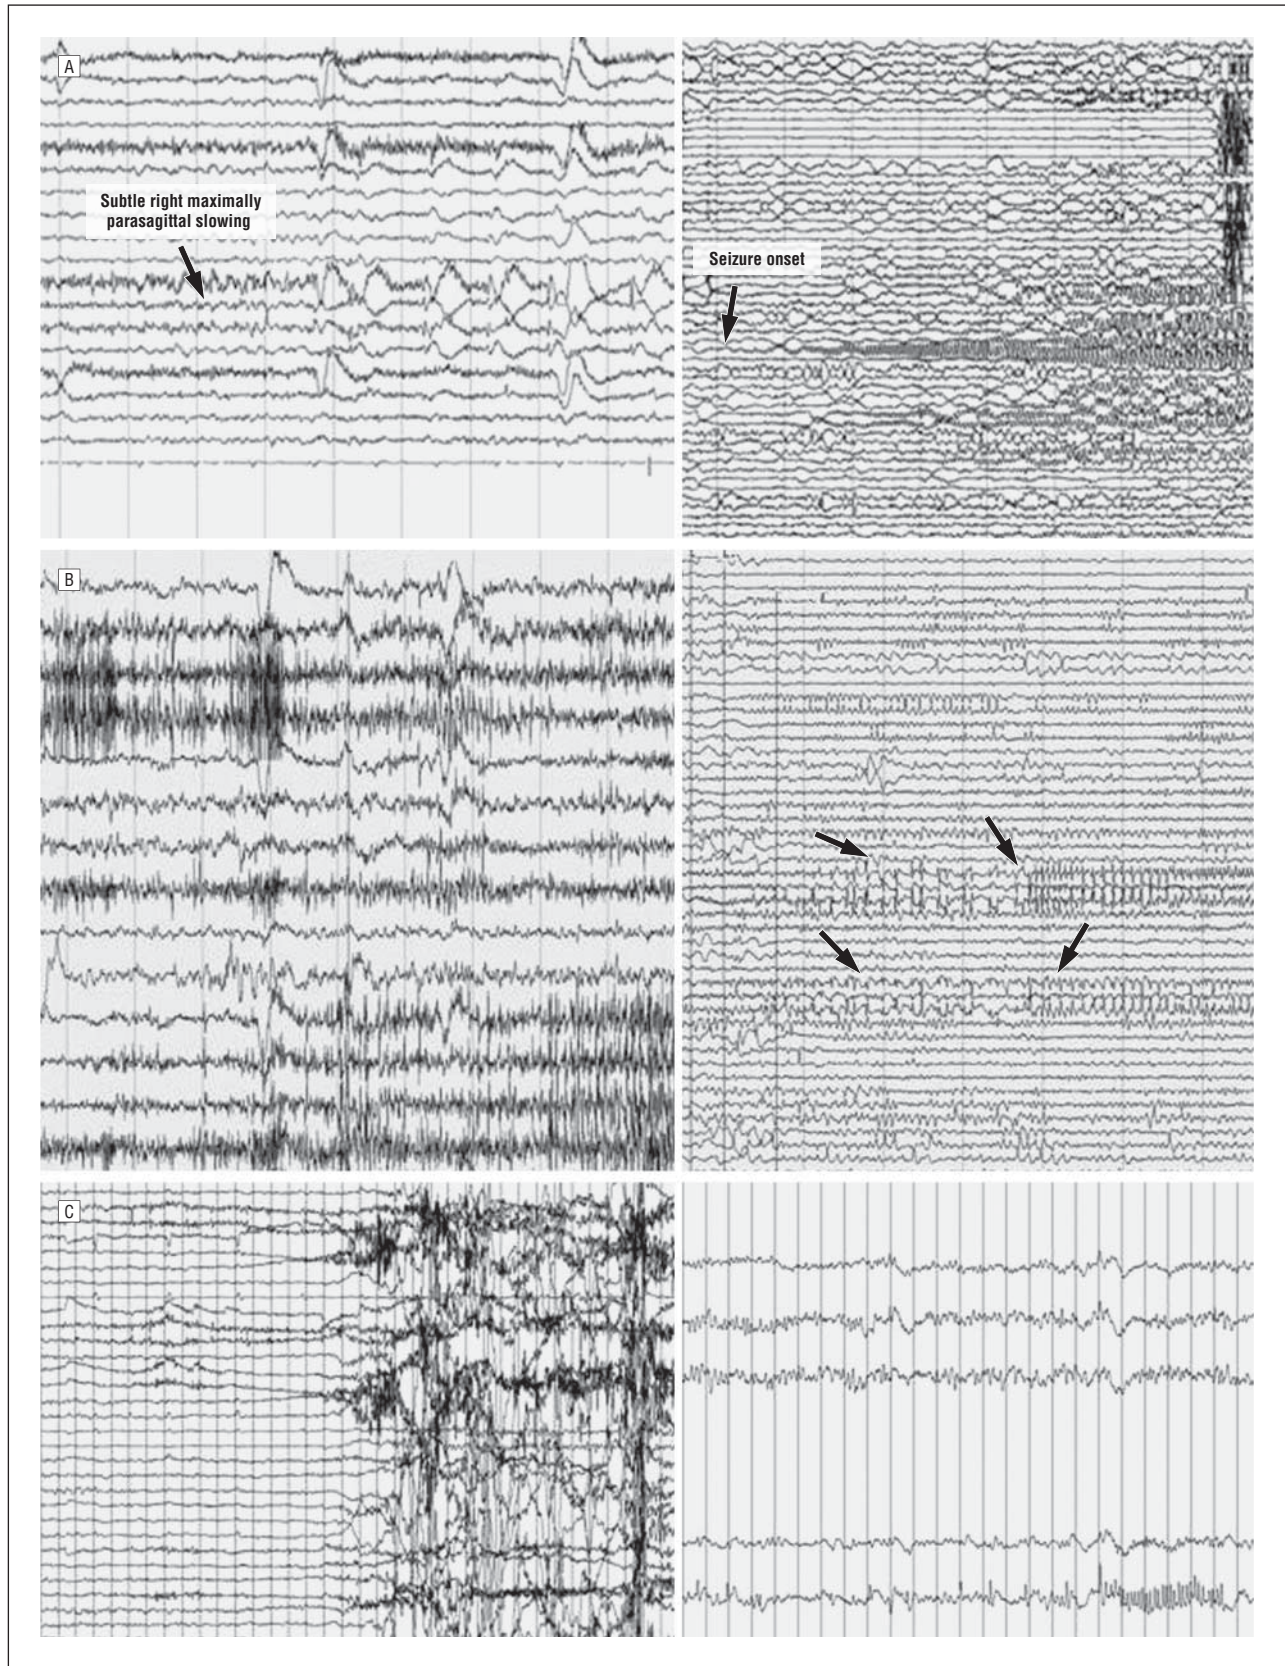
Selected electroencephalography (EEG) panels. A, The left panel is a surface EEG monitoring of seizure onsets showing relatively mild subtle slowing in the right hemisphere. The right panel is an invasive EEG via a 64-contact grid. Note the focal onset of seizure activity, which corresponded to the lesion noted on magnetic resonance imaging (arrows). B, Surface (left panel) and invasive (right panel) EEG monitoring. Note the lack of ictal signature on surface monitoring and the recurrent volleys of spikes seen with invasive surface monitoring (arrows) using a grid array that corresponded to a regional area ultimately parallel to the noted lesion on neuroimaging. C, Surface monitoring (left panel) identifies only muscle artifact but since the region of seizure onset is so small, no abnormalities are noted at seizure onset on the scalp. The right panel denotes recurrent trains and volleys of spikes in the region of the ultimately resected focal cortical dysplasia.
